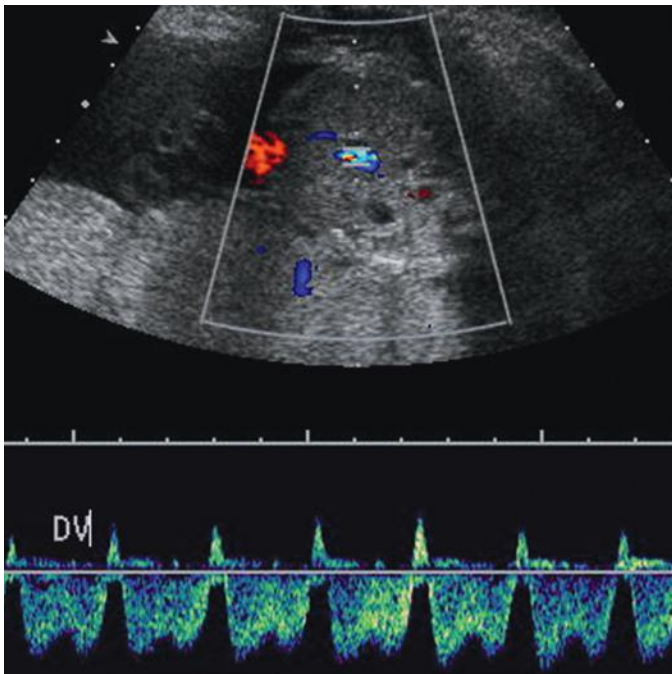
Abnormal spectral Doppler waveform of the ductus venosus (DV) with reversed a wave flow resulting from decline and subsequent reversal in forward flow during atrial systole in this fetus with severe fetal growth restriction.
